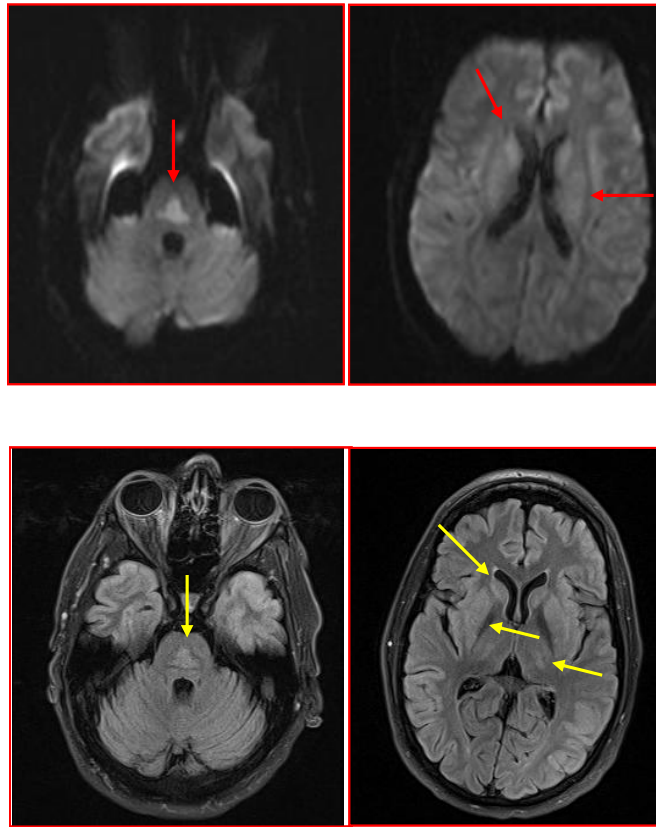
DWI shows diffusion restriction (red arrows), in the central pons and also subtle similar findings in bilateral central thalami, bilateral caudate nuclei and bilateral putamen. There is an associated increased hyperintensity on FLAIR images (yellow arrows) of the same distribution.
